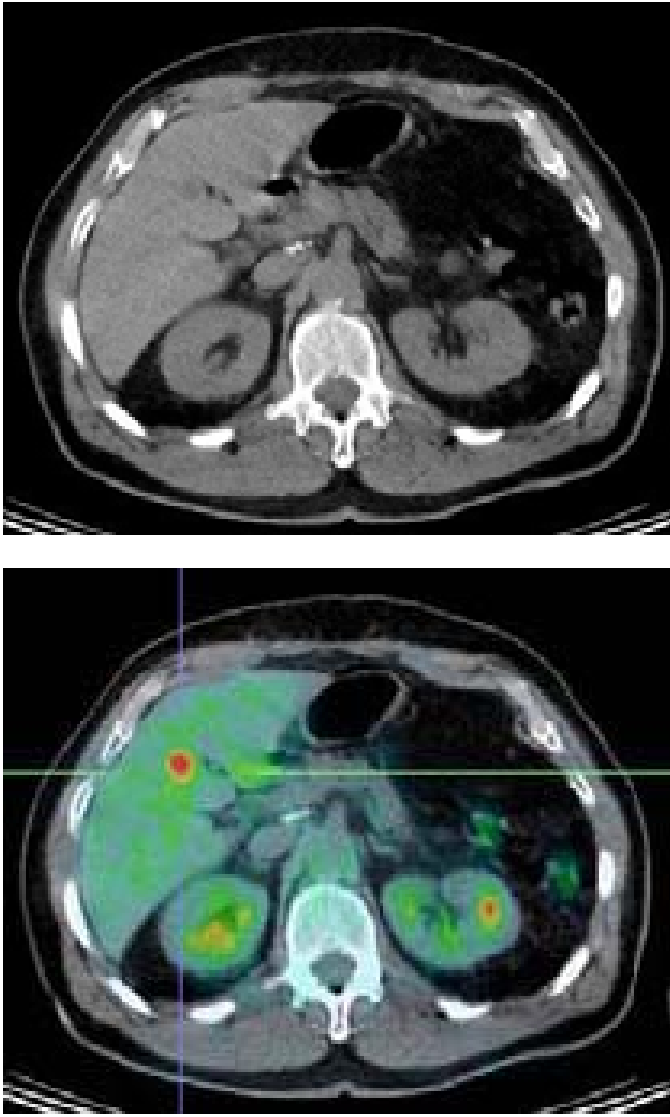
In the standard CT image (above) , the liver appears normal. Combined FDG PET/CT imaging (below) clearly reveals a focus of increased metabolic activity. Based on this information, closer inspection of the CT image reveals a slightly hypointense region corresponding to the region of increased PET tracer uptake.
